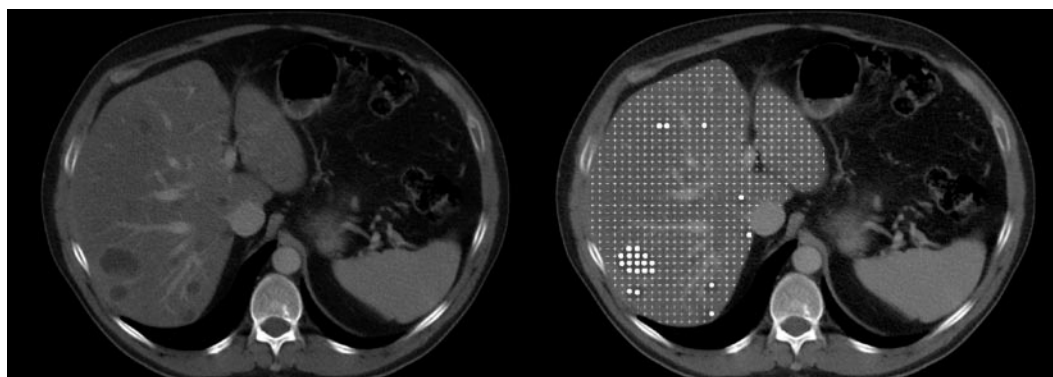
Volume quantification method using stereology. Original CT image of a baseline liver scan acquisition from patient 3 (left), and the same liver scan with a stereology grid showing points within the liver parenchyma (crosses) and within cysts (full circles).
